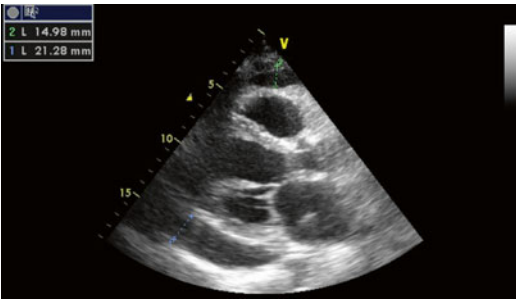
Two-dimensional transthoracic echocardiogram showing the parasternal long-axis view. A moderate-sized pericardial effusion is present posteriorly
